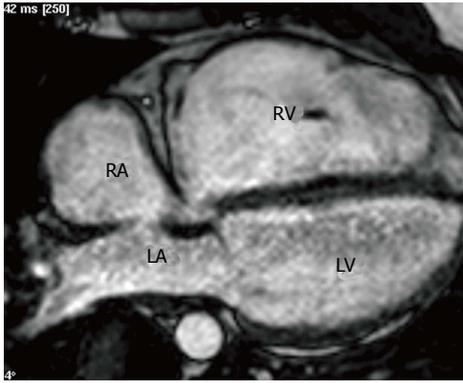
Arrhythmogenic right ventricular dysplasia. Four-chamber cine steady state free precession image shows wall shows aneurysmal dilation of the right ventricle. There was also low ejection fraction (ejection fraction-35%) and severe right ventricle dilation (end diastolic volume index-130 mL/m²). These magnetic resonance imaging features satisfy one major criterion for arrhythmogenic right ventricular dysplasia. RA: Right atrium; LA: Left atrium; RV: Right ventricular; LV: Left ventricular.
